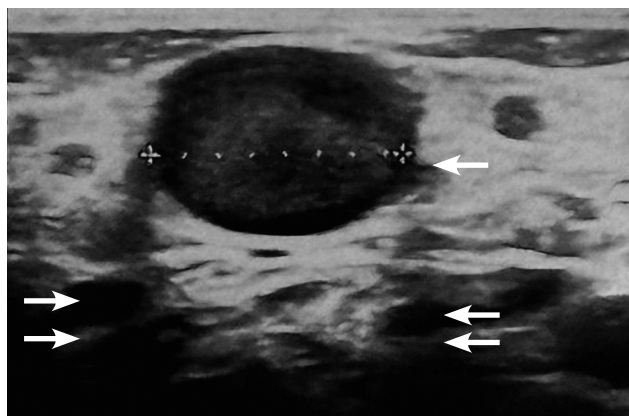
Ultrasound of the veins of the upper third of the lower leg, patient Ch., 10 years old. Diagnosis: embryonic type dysplasia of the great veins of the left lower extremity. The lateral embryonic vein is indicated by a single arrow; the dilated tributaries of the embryonic vein are indicated by double arrows
